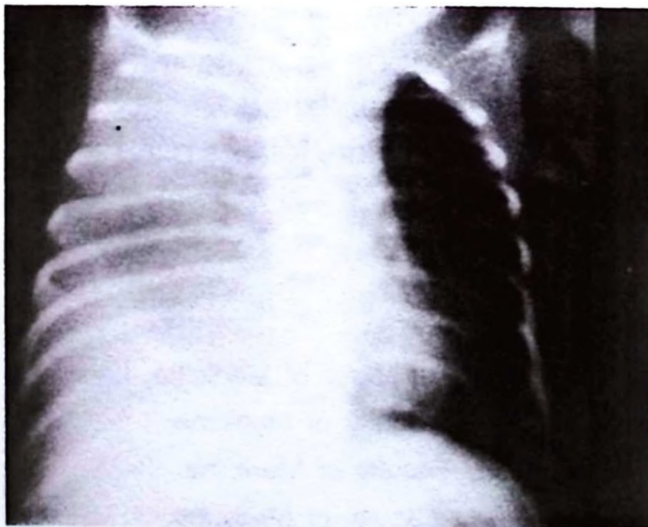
Chest x-ray of the baby before thoracentesis.
